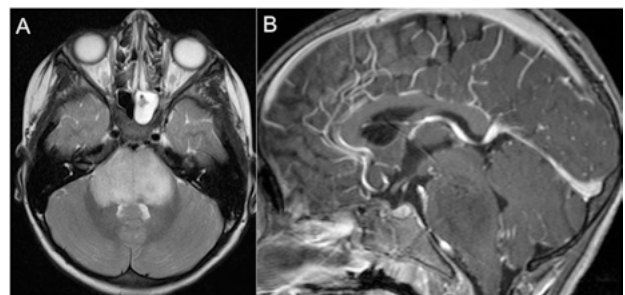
Diffuse intrinsic pontine glioma characterized by a hyperintensity on T2 (A, axial view) and iso-hypointensity on T1 weighted MRI (B, sagittal view). In this case, the lesion did not have significant contrast enhancement.
